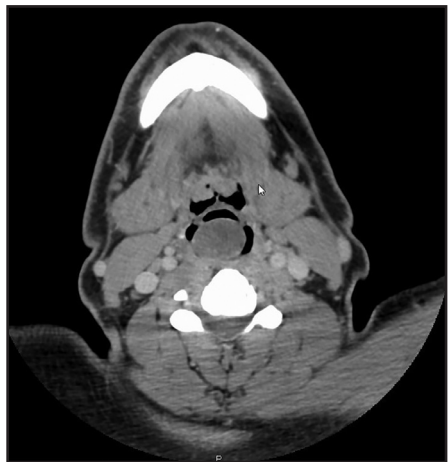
Axial CT image shows a low-attenuation soft-tissue mass posterior to the epiglottis that significantly narrows the airway.
